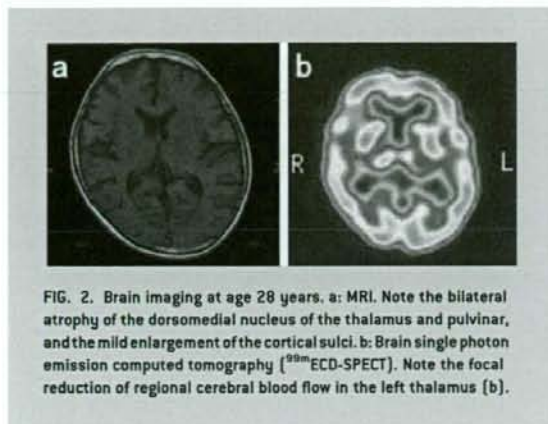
Brain imaging at age 28 years. a: MRI. Note the bilateral atrophy of the dorsomedial nucleus of the thalamus and pulvinar, and the mild enlargement of the cortical sulci. b: Brain single photon emission computed tomography (^{99m}Tc -ECD-SPECT). Note the focal reduction of regional cerebral blood flow in the left thalamus (b).
